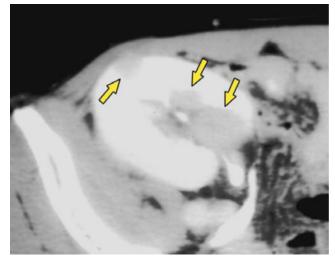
CT one year after transplant showing several new masses within the renal allograft.
